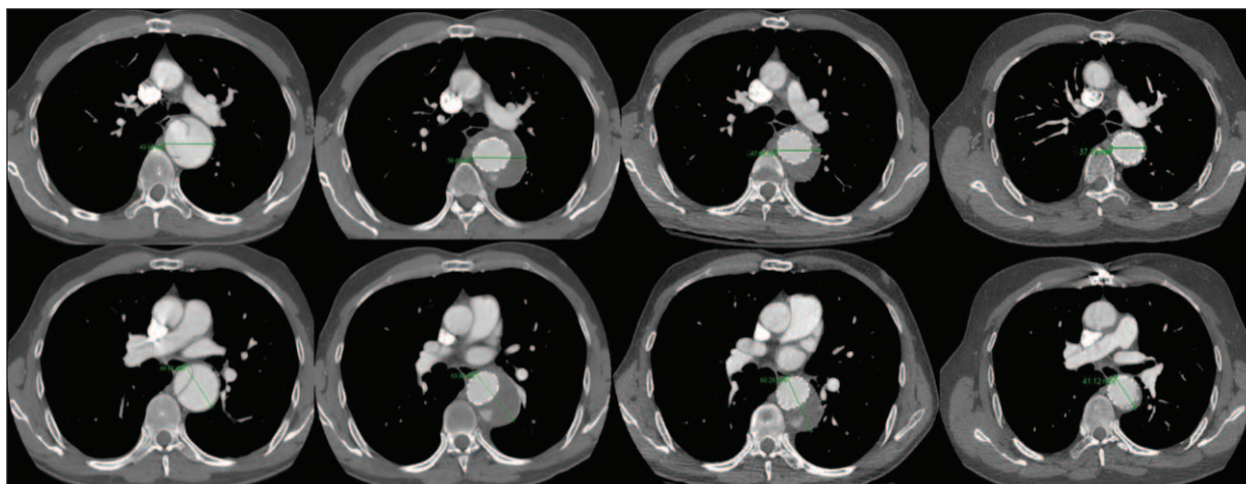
Six-year follow-up with representative axial CT images taken at the level of the carina (top panels) and the top of T-7 (lower panels) on October, 11, 2007; February 27, 2008; July 26, 2009; and December 4, 2013; respectively.
